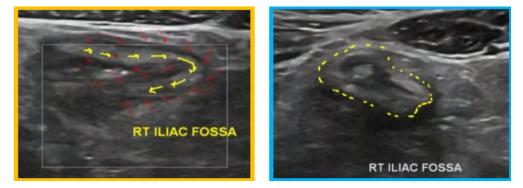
Ultrasound abdomen and pelvis shows in both longitudinal (A) and transverse (B) section shows mural thickness of tubular structure in the right lower abdominal quadrant (appendicitis versus ileitis).
